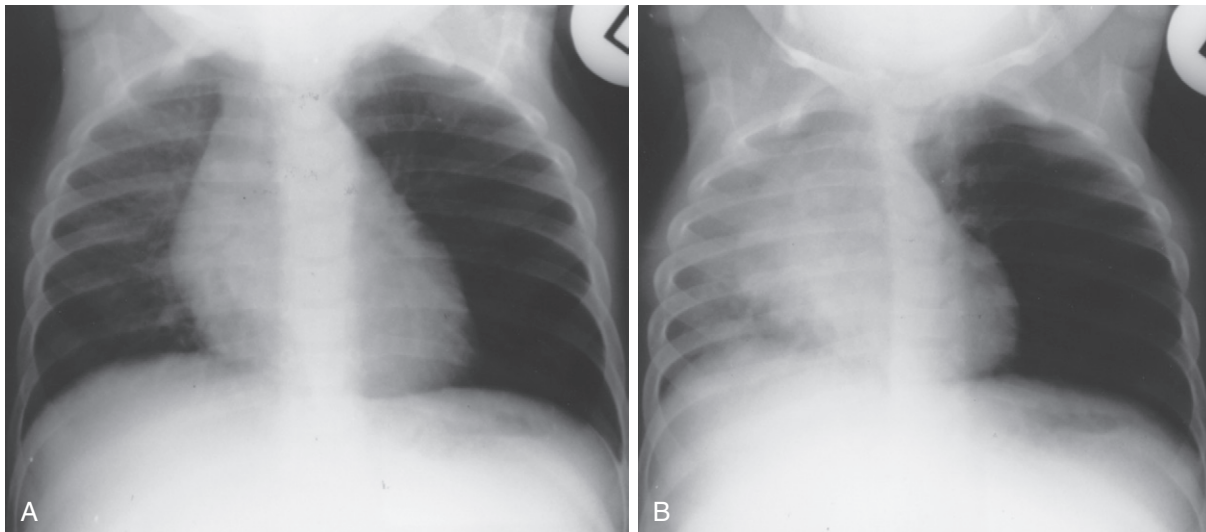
Inspiratory (A) and expiratory (B) radiographs of 8-year-old boy with left airway foreign body (peanut). No foreign object is visible on plain films, but the expiratory film shows overinflation of the left lung with mediastinal shift to the contralateral side.
